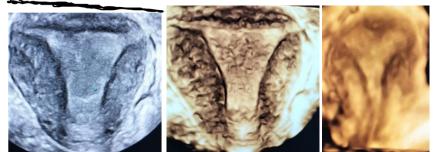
Transvaginal A. coronal B. 3D and C. Transabdominal 3D ultrasound images of the uterus.
